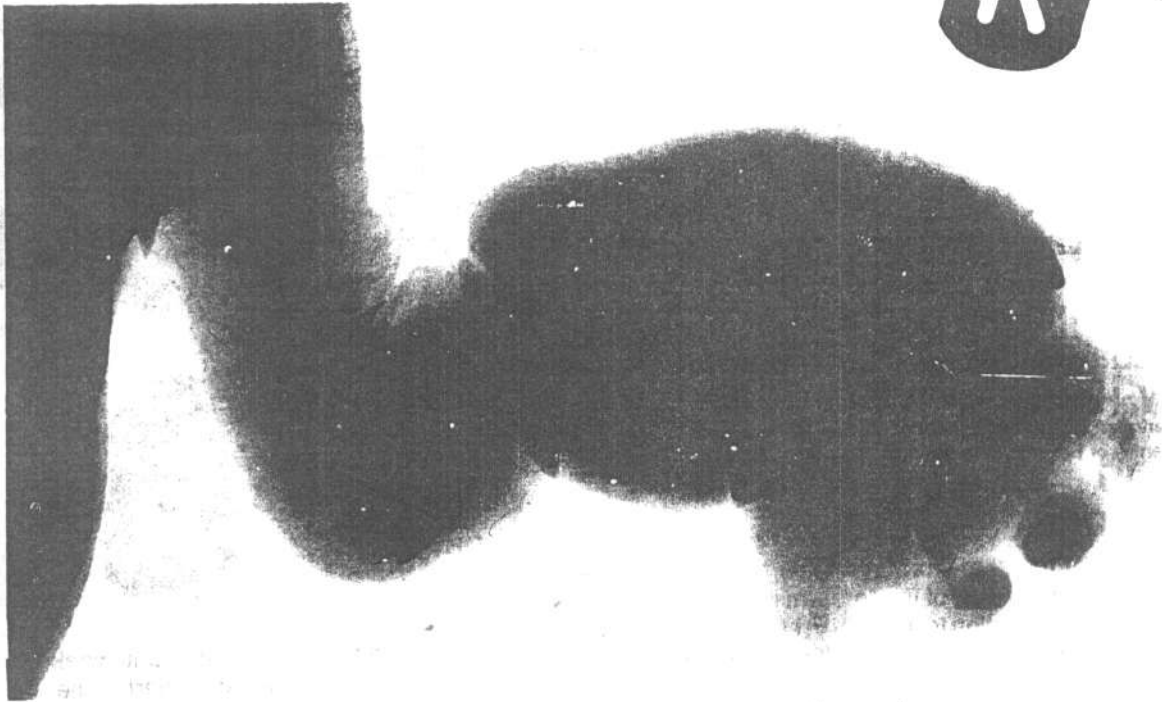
X-ray of the right forearm, demonstrating discontinuity of the radius and ulna at the level of the constriction.
